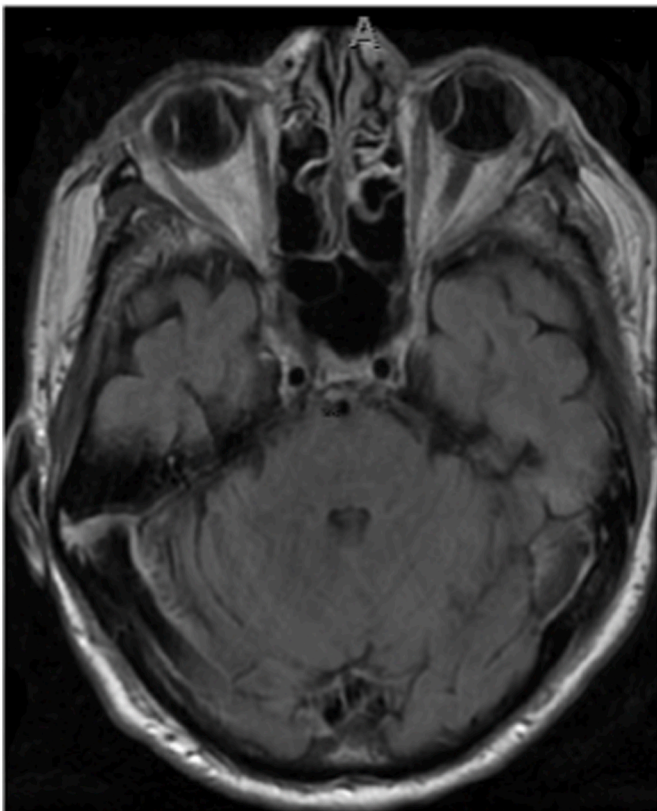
Flare T2-weighted MRI demonstrating bilateral choroidal effusions.
